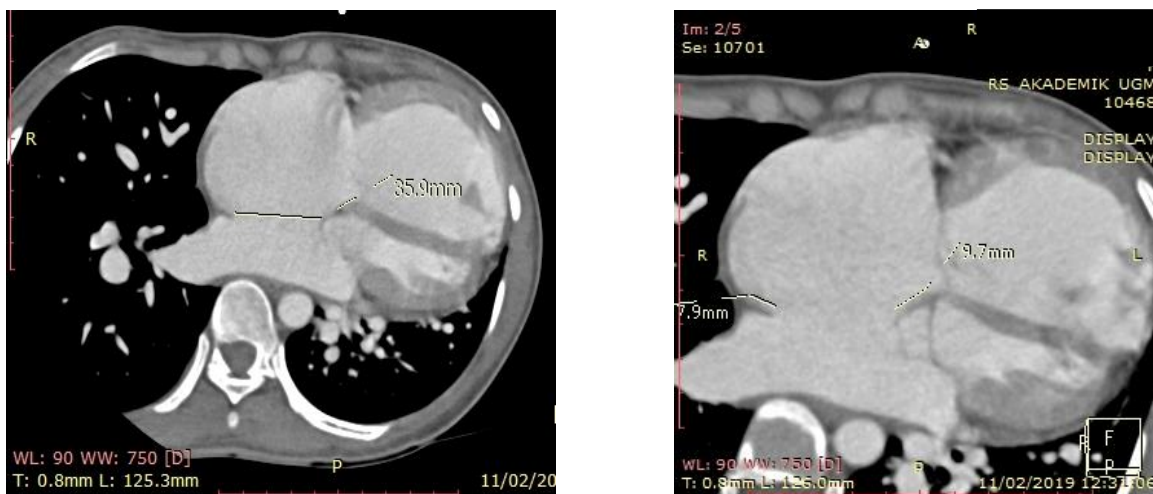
Cardiac CT revealed, a) largest diameter of secundum ASD, b) size of superior and mitral rim with anomaly of mitral rim
